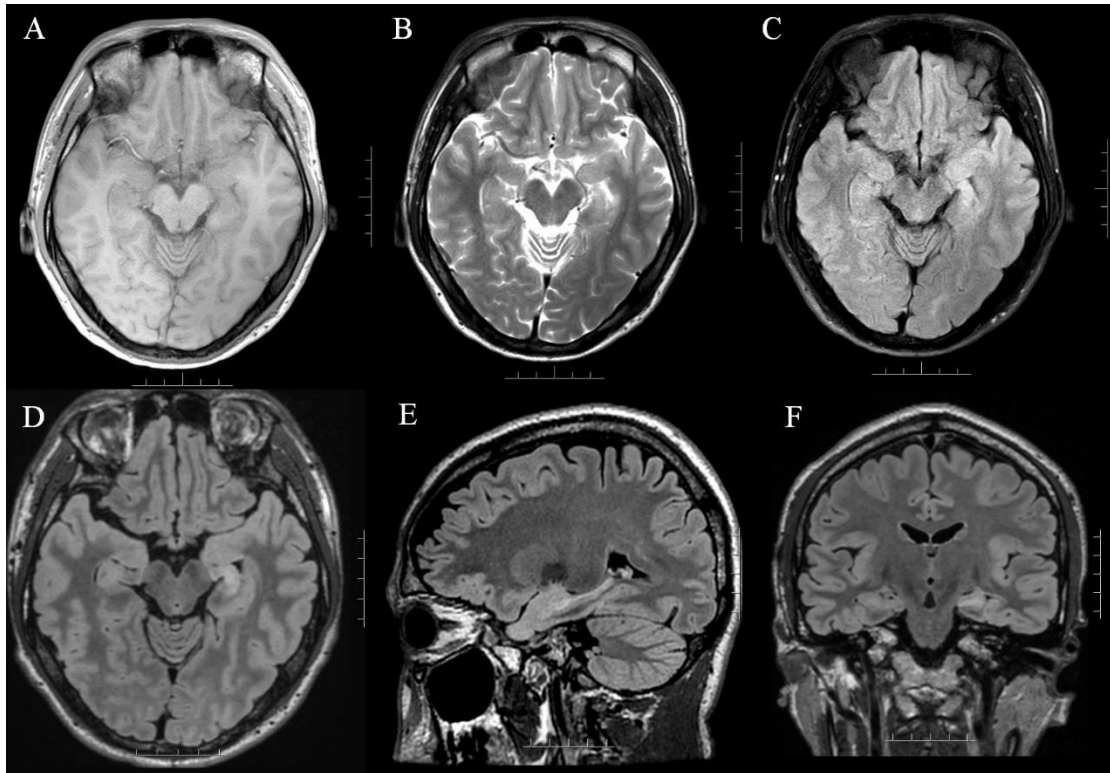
Routine head MRI: T1-weighted image (A), T2-weighted image (B), and T2-FLAIR image (C) showed no obvious abnormalities in the hippocampus; Hippocampal thin-slice MRI: T2-FLAIR axial image (D), sagittal image (E), and coronal image (F) showed symmetric bilateral hippocampi, with reduced volume of the left hippocampus and signal hyperintensity on FLAIR imaging. MRI = Magnetic Resonance Imaging.
